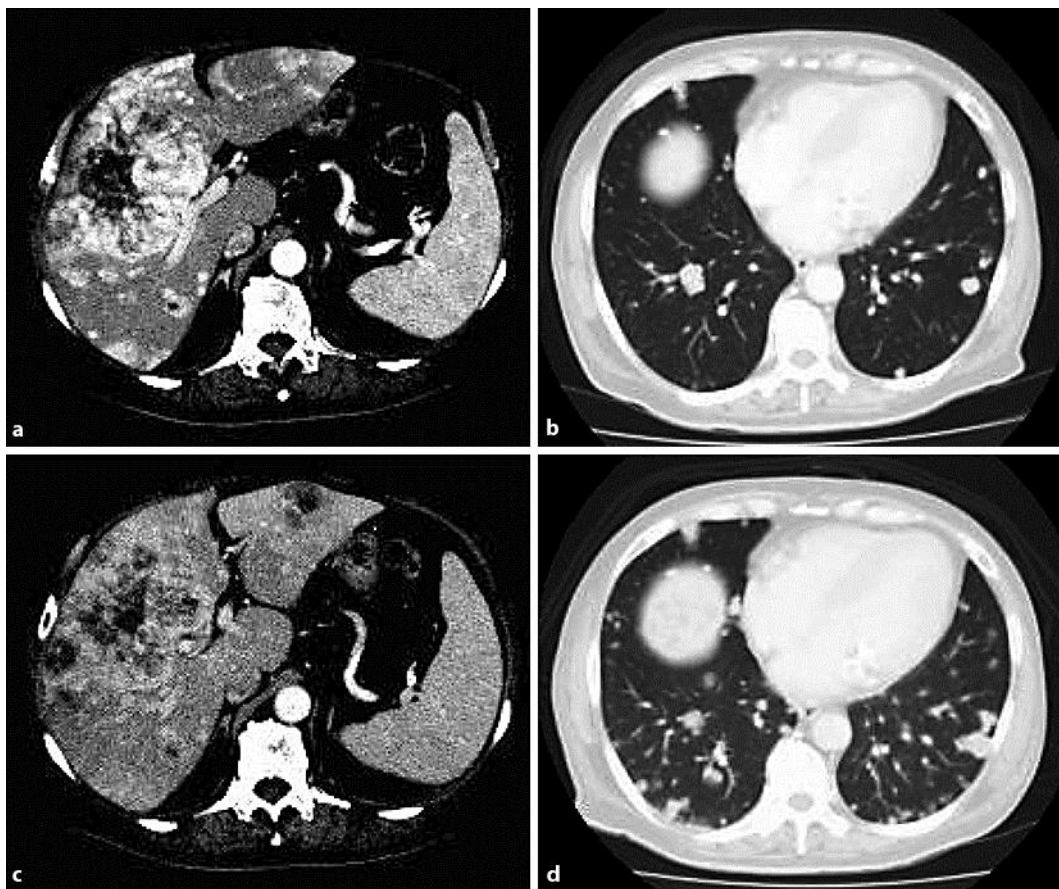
CT scan images before and after the administration of sorafenib. a, b Images before therapy. c, d Images after therapy. By the administration of sorafenib, the size of the liver tumors had not changed (a to c), but the number of lung metastases had increased (b to d).
